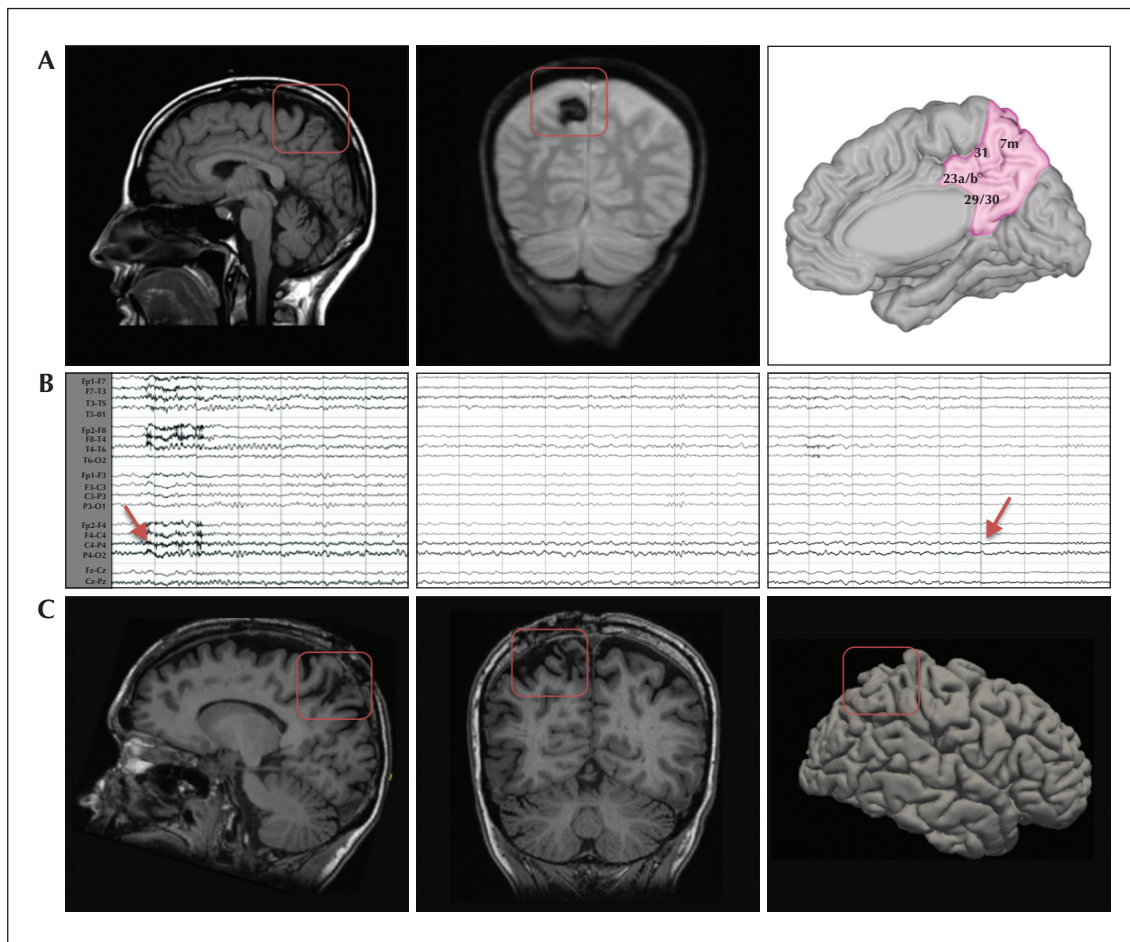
(A) Sagittal view of the T1-weighted MRI scan (left) and coronal view of the gradient-echo MRI scan (centre) showing the cavernous malformation in the right precuneus region. The sagittal view of the MNI space is shown with the PMC region, highlighted in pink (right). (B) EEG graph showing the onset (left), progression (centre), and end (right) of seizure activity in the precuneus region recorded under a sensitivity of 7 μ V, time constant of 0.1 seconds, and high filter of 15 Hz, over a time period of 7-8 seconds. The time at onset (red arrow on the left) and offset (red arrow on the right) is denoted on the precuneal channels (bold lines). (C) Sagittal (left) and coronal (centre) view of the T1-weighted MRI scan showing the patient's brain after resection. The lateral view of the reconstructed 3D rendering of the MR scan in 2018 is also shown on the right.
